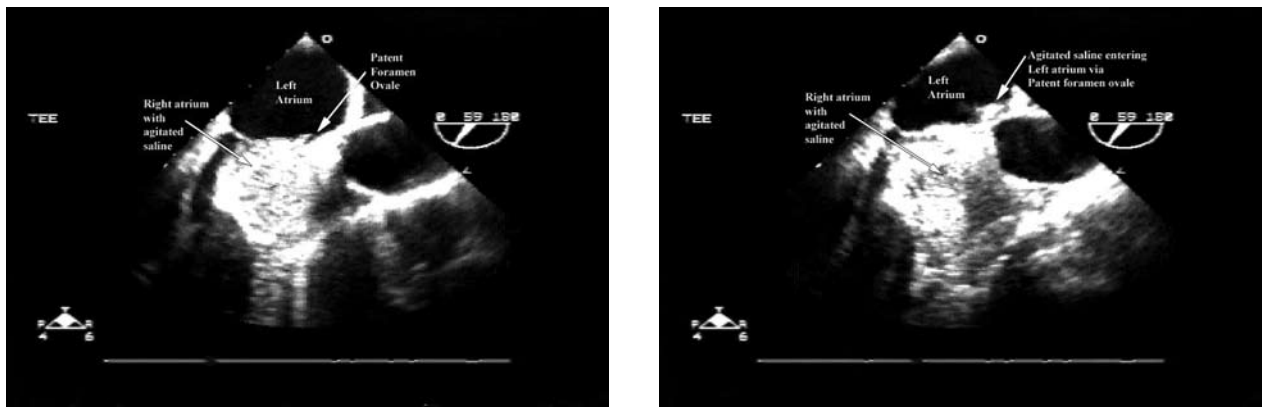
Transesophageal echocardiogram shows agitated saline in right atrium entering the left atrium via a patent foramen ovale (*right*).
